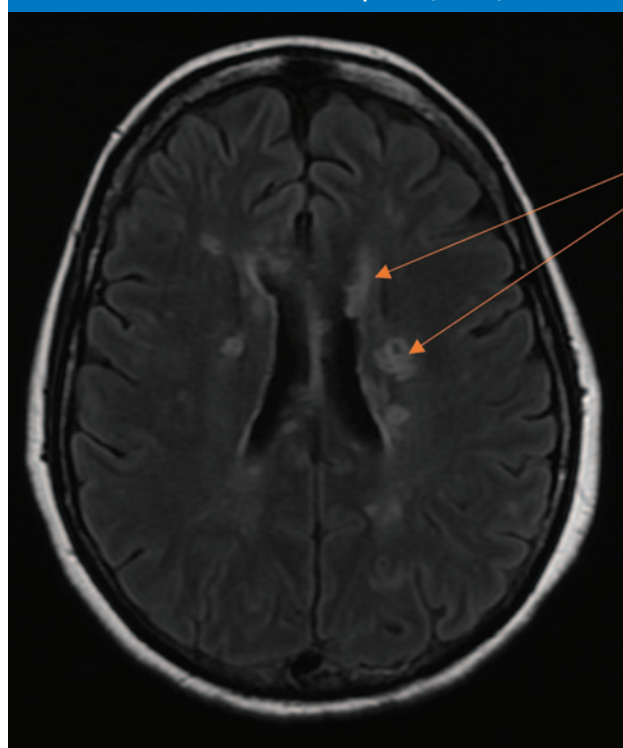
Repeat MRI brain revealed multiple new areas of infarction in bilateral cerebral hemispheres (arrows).
